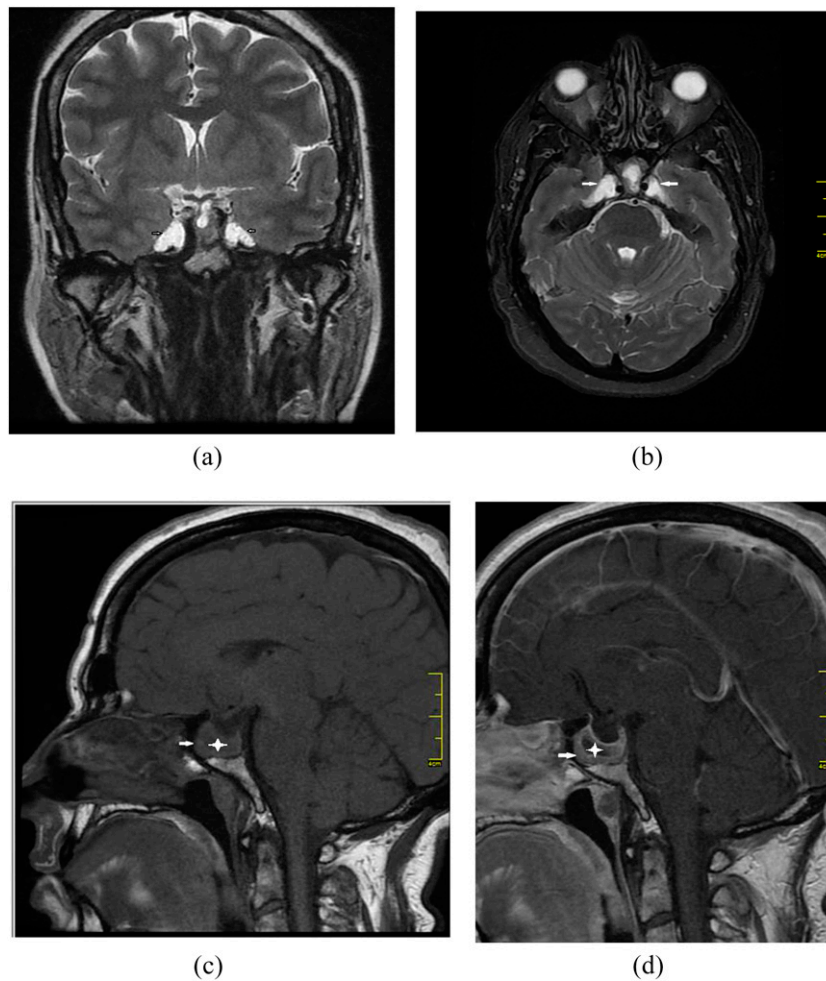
A 48-year-old female presented with irregular menstrual cycles. Coronal T_2 weighted (a) and axial T_2 weighted (b) MR images show bilateral petrous apex cephalocele (arrows). Sagittal T_1 weighted pre-contrast (c) MR image shows pituitary expansion (arrow) and focal hypointense area inside of the gland (asterisk). Sagittal T_1 weighted post-contrast (d) MR image shows non-enhancing cystic lesion (asterisk) in homogeneously enhancing pituitary gland (arrow).
